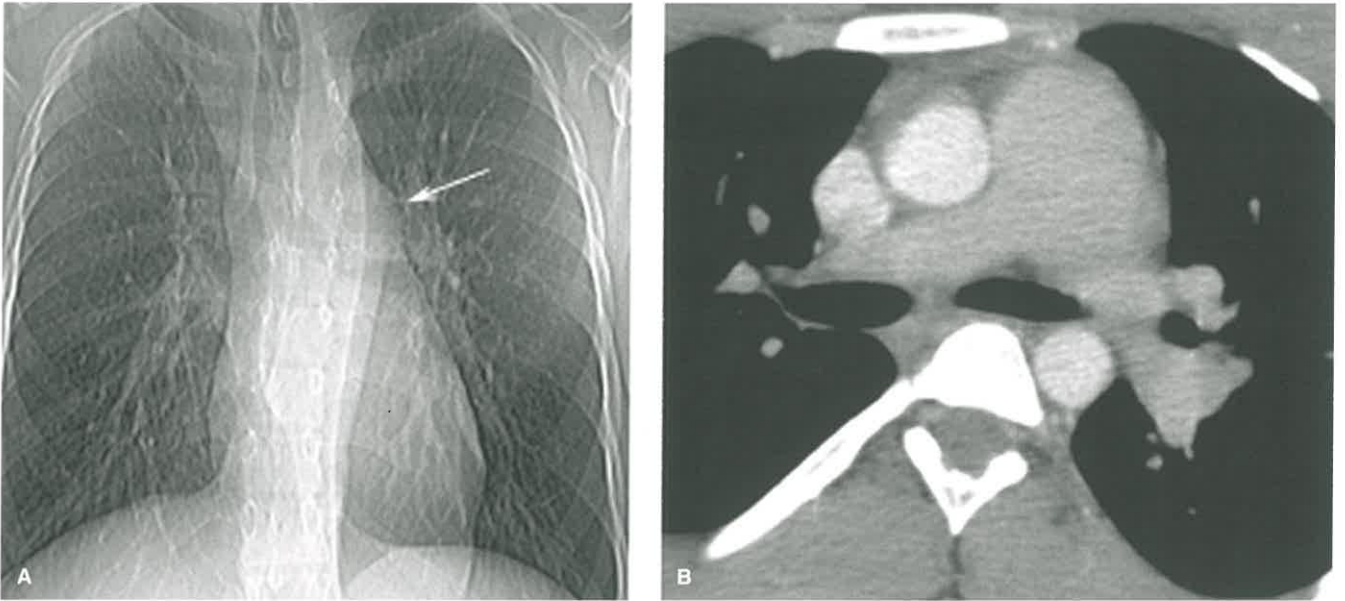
Unilateral Hilar Enlargement From Idiopathic Dilatation of the Pulmonary Artery. A: Scout view from chest CT shows abnormal convexity in the region of the main pulmonary artery (*arrow*). Note thoracic scoliosis. B: Enhanced CT scan shows dilated main pulmonary artery with normal right and left pulmonary arteries. Physical examination and echocardiogram showed no evidence of pulmonic valve disease.
